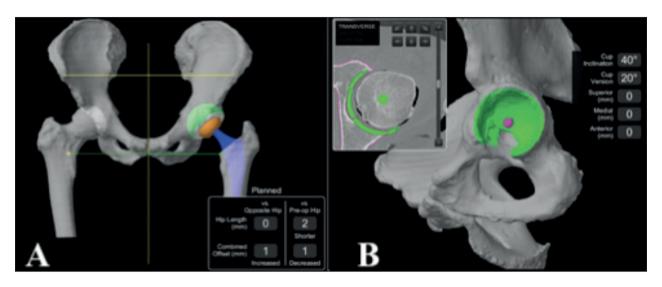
The 3D preoperative model based on patient's CT data. On panel A estimated hip length and combined offset are compared to opposite hip. On panel B the orientation and depth of the acetabular component in the transverse view of the hip joint are showed.
